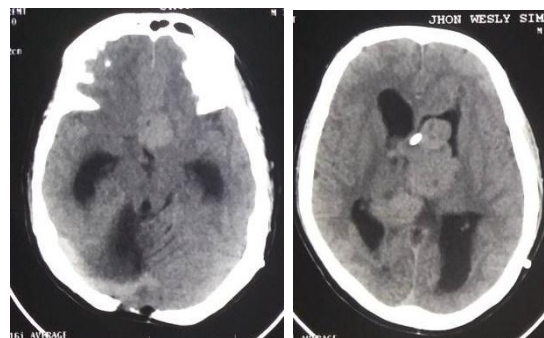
Non contrast CT Scan of brain 2 years later shows multiple isodense lesion intraventricular
